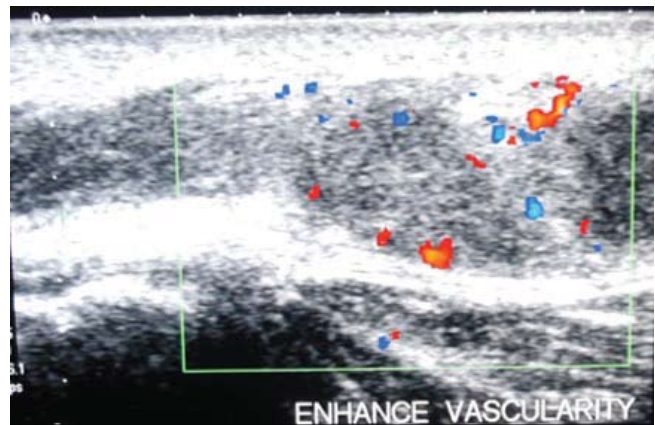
Color doppler USG of left common peroneal nerve of Leprosy patient showing blood flow signals suggestive of neuritis
